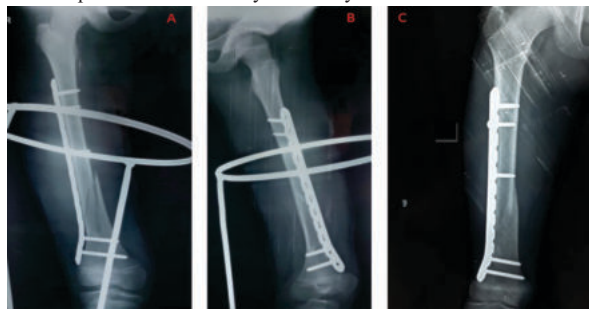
In a 8 year old girl distal third fracture treated with Sub-muscular plating A) AP views immediately post surgery; B), C) AP and Lateral radiograph at 3 months follow-up.
